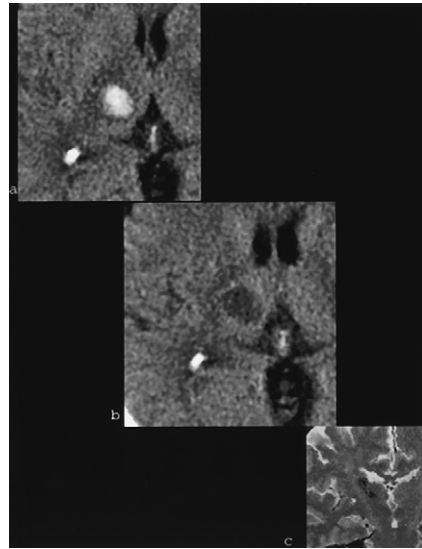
Hypertensive hemorrhage. (a) Small acute hematoma in the right thalamus. (b) A well-defined area of decreased attenuation in the thalamus on CT obtained 23 days after ictus is difficult to identify as evolving hematoma without the previous study. (c) More than a year later, T2-weighted MRI demonstrates a linear hemosiderin deposition.
